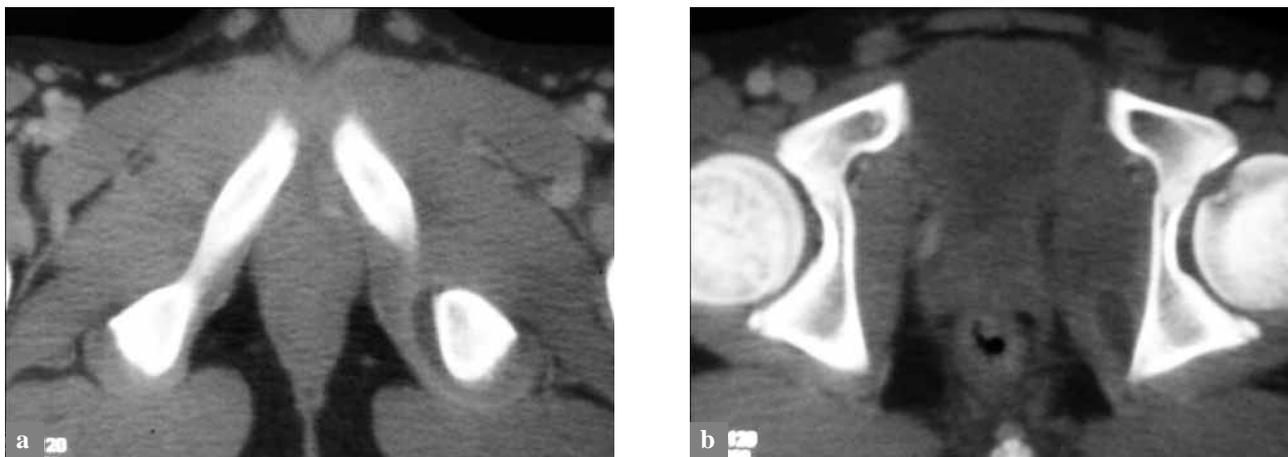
Axial CT images of pelvis at level of ischial tuberosity (a) and of fovea (b)
